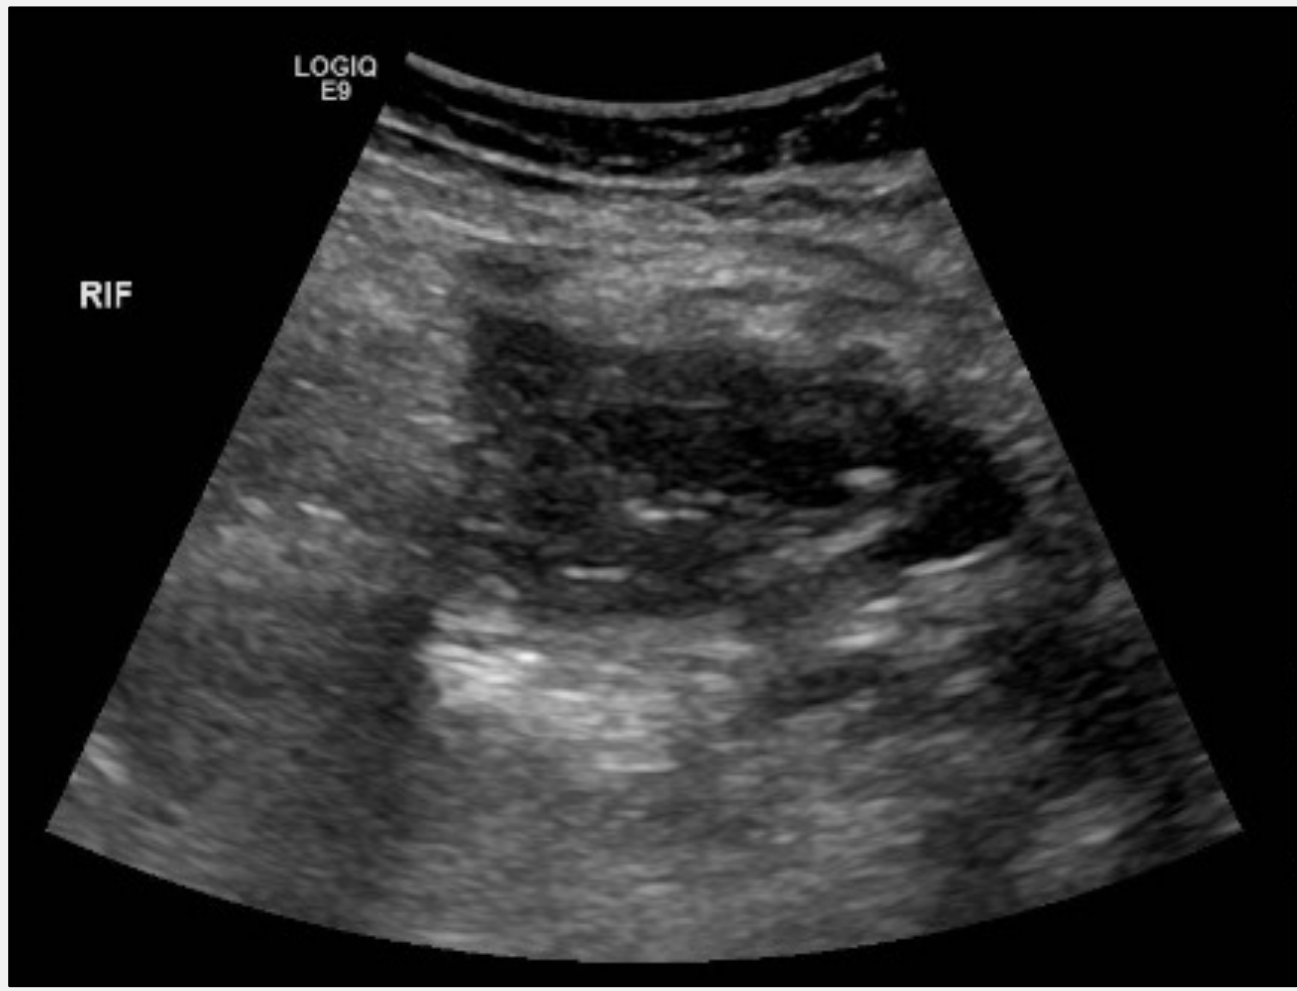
Ultrasound one month later: Shallow fluid collection containing debris encasing the transplant kidney.
